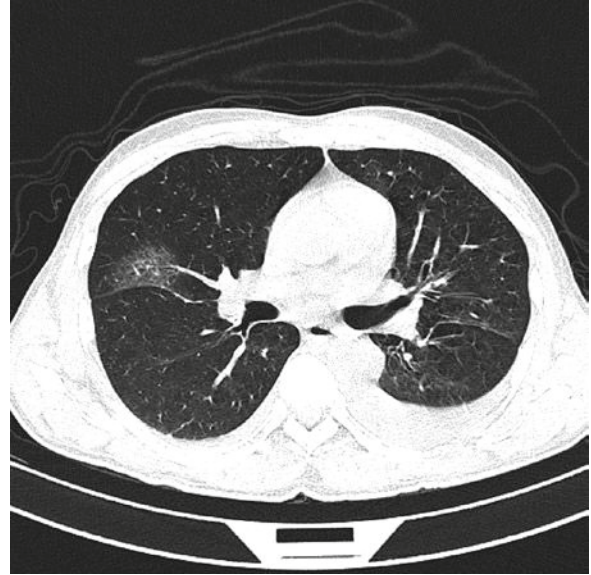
Chest CT showing ground-glass infiltrates and pleural effusion in a non-neutropenic hematopoietic stem cell transplant recipient with invasive fusariosis
